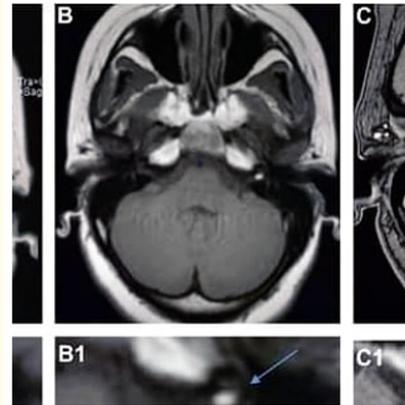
Lipochoristoma depicting hyper-intense signals upon T1 weighted magnetic resonance imaging [12].
